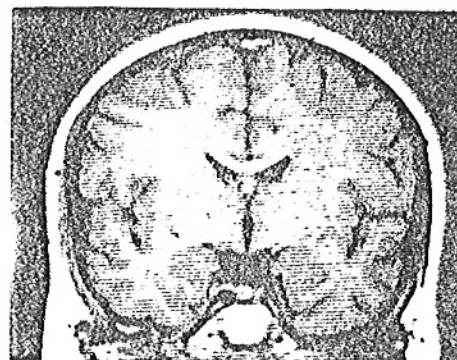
Case 8. Frontal MRI shows symmetrically abnormal signals in the internal segment of the globus pallidus bilaterally (increased signal on T1 sequence).
